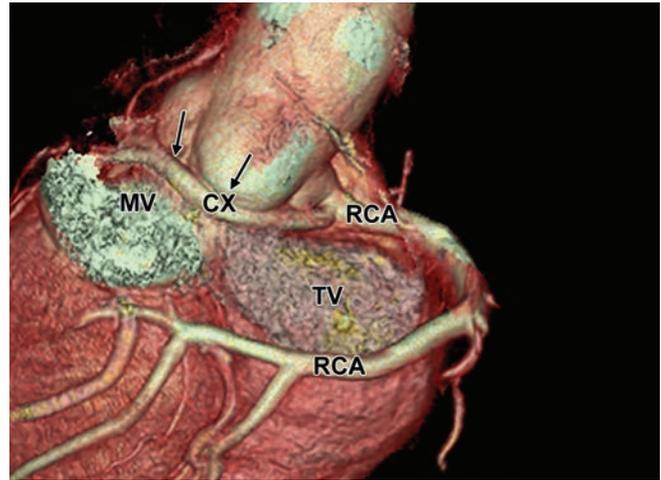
Coronary computed tomography angiography with abnormal origin of circumflex coronary artery (CX) from right coronary artery (RCA), with retroaortic course. Mitral valve (MV). Tricuspid valve (TV).
